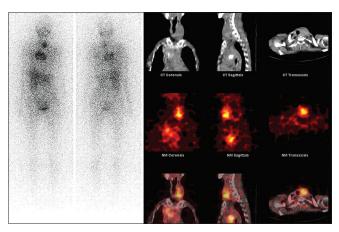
A 52-year-old female known case of MEN2A with status post excision of pheochromocytoma was referred for lodine-131 metaiodobenzyl guanidine in view of elevated calcitonin. The scan showed increased tracer uptake in the neck and thorax. Hybrid single photon emission computed tomography/computerized tomography images localized the uptake to the enlarged left lobe of thyroid gland and calcified lesions in the anterior mediastinum, likely due to medullary thyroid carcinoma with mediastinal lymph nodal metastases which was confirmed later
